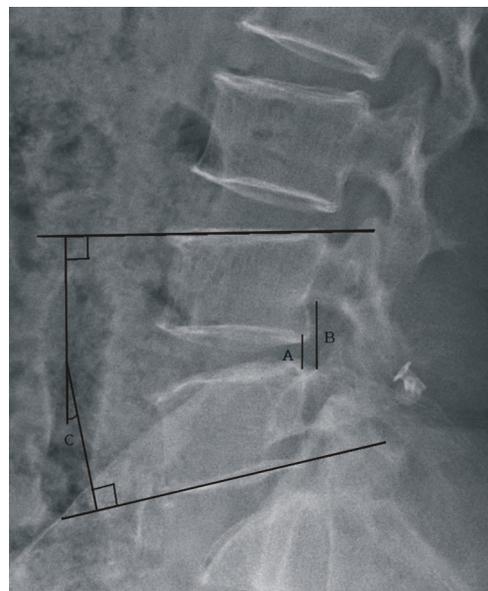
Lateral standing radiograph obtained after implantation of DIAM at the L4-5 level. A: disc height, B: foraminal height, C: extension angle.
